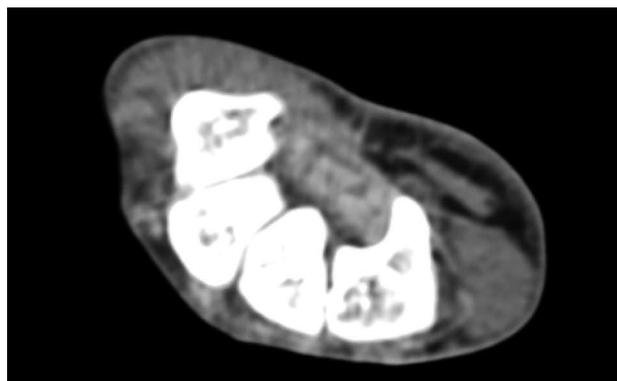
Axial computed tomography scan shows bony part of carpal tunnel at the level of outlet. Bony structures from left to right are HAMATE, CAPITATE, TRAPEZOID, TRAPEZIUM. FR (arrow) b and flexor tendons can be detected by computed tomography scan.
